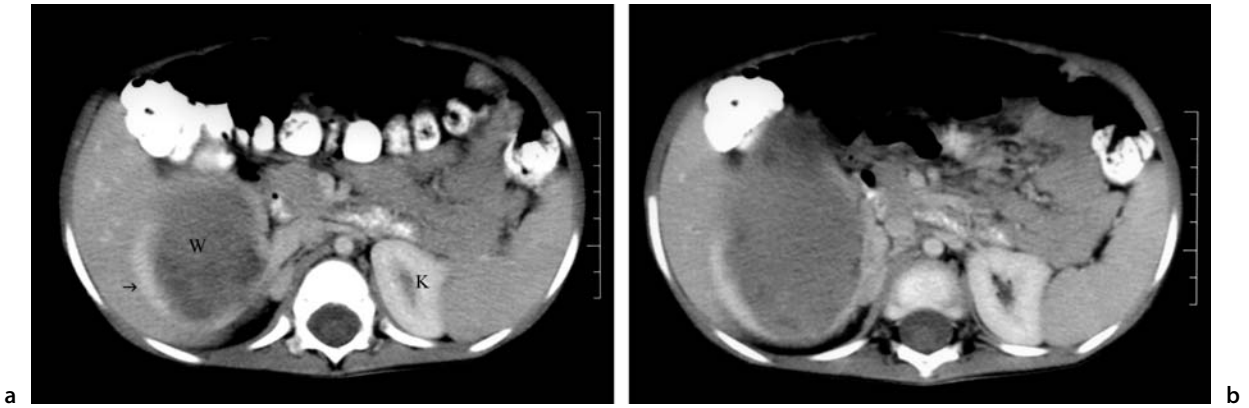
Wilms tumor on CT
